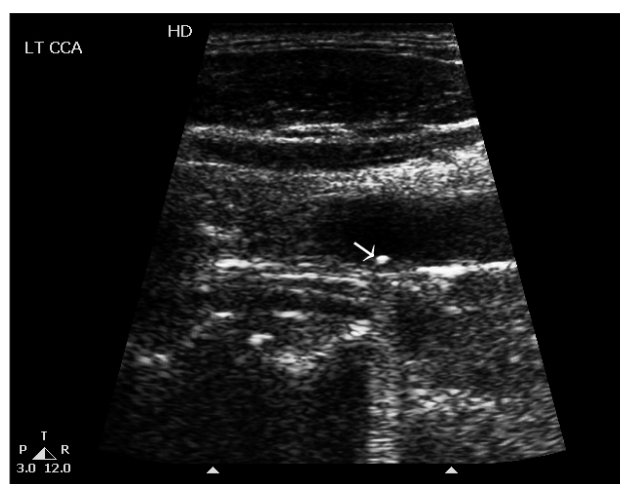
A Duplex ultrasound six months after the injury depicts the subintimal pellet in the initial position with an acoustic shadow.
